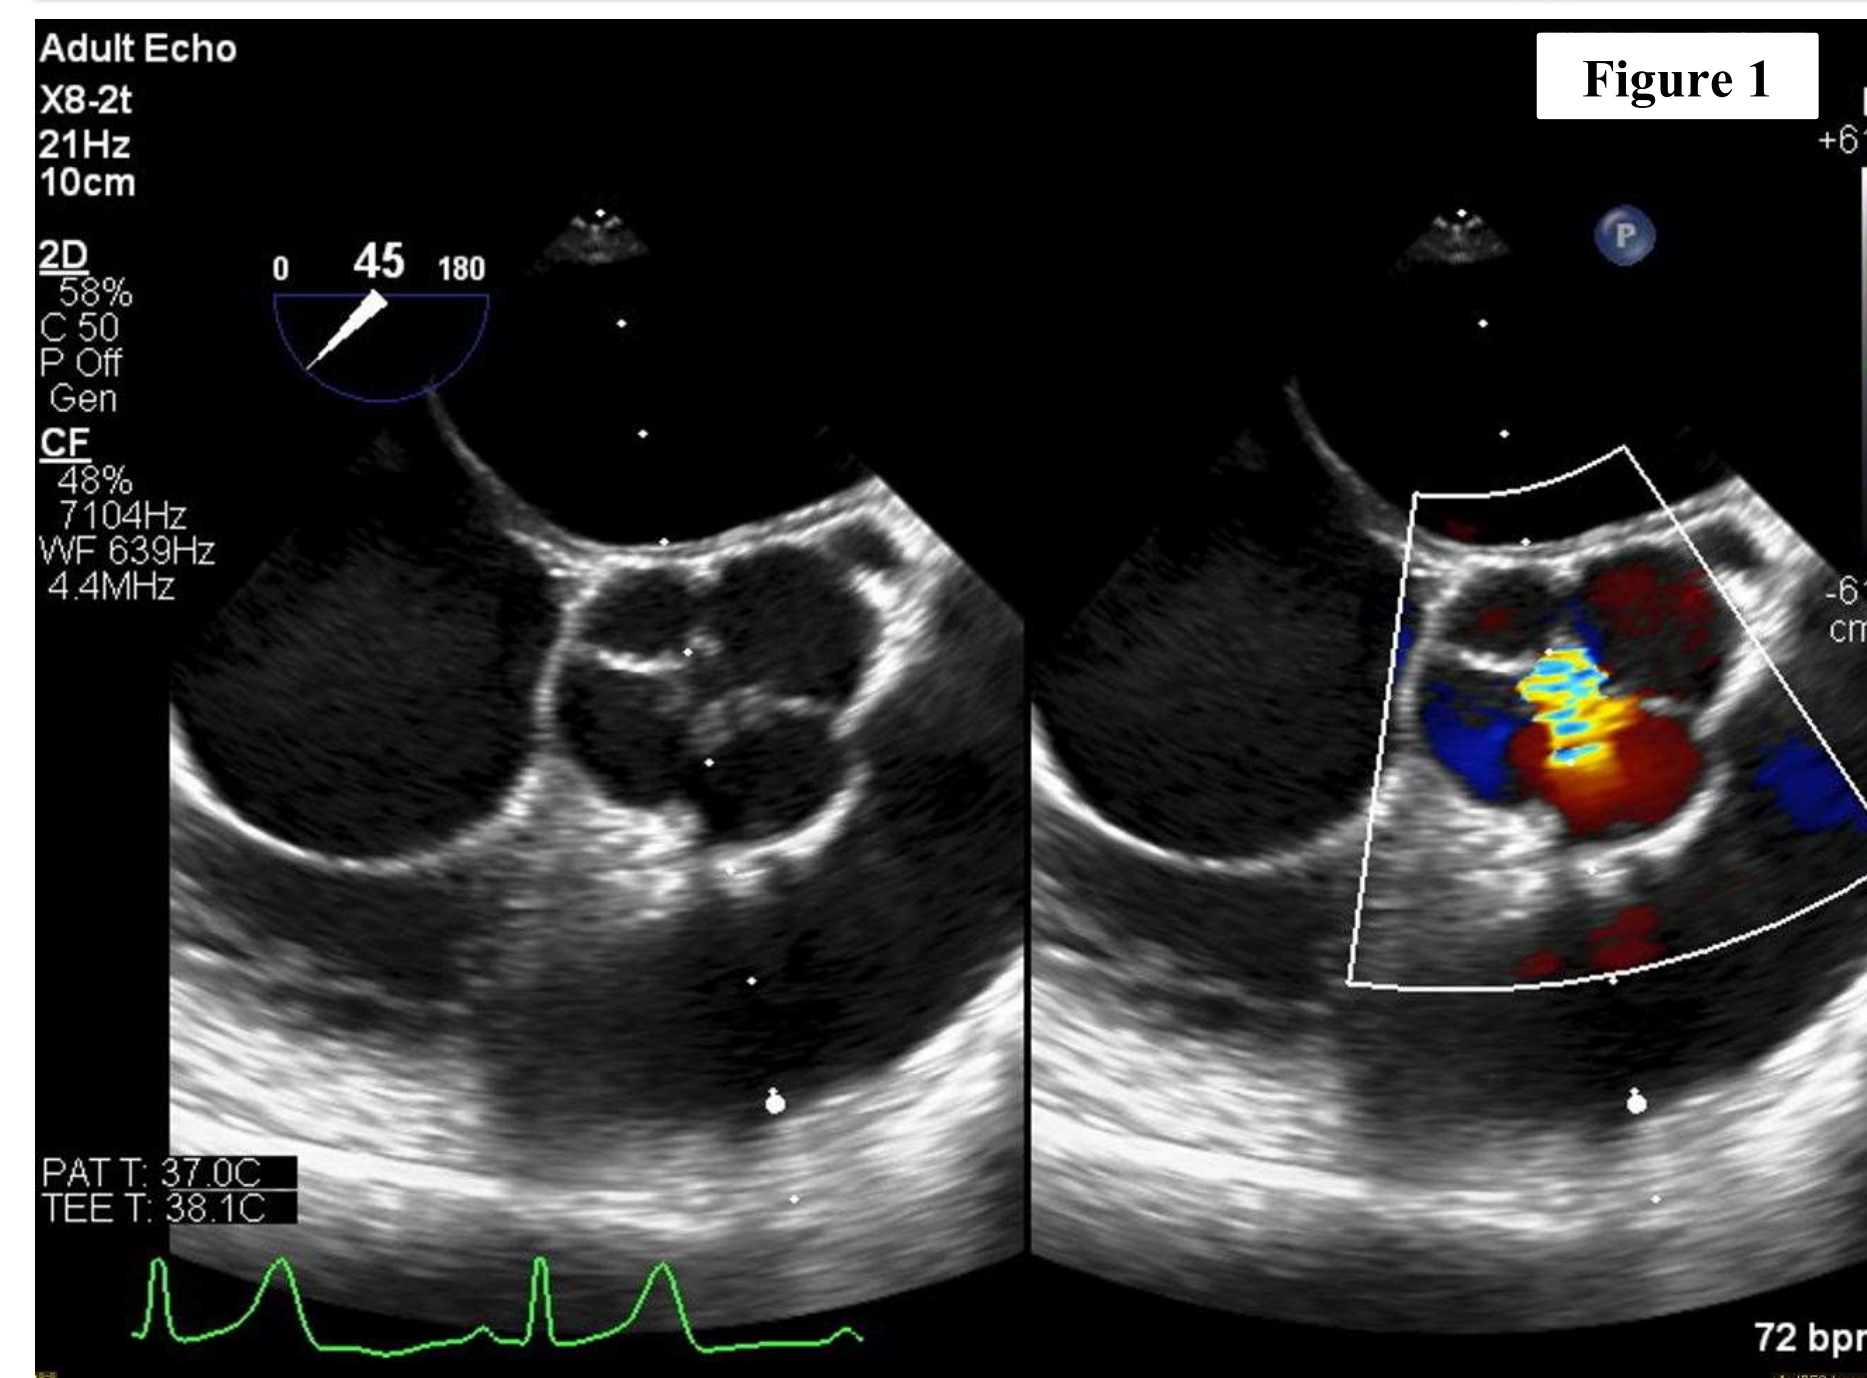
Transesophageal echocardiogram. Mid-esophageal level, aortic valve short axis view. Doppler significant for severe AI.
